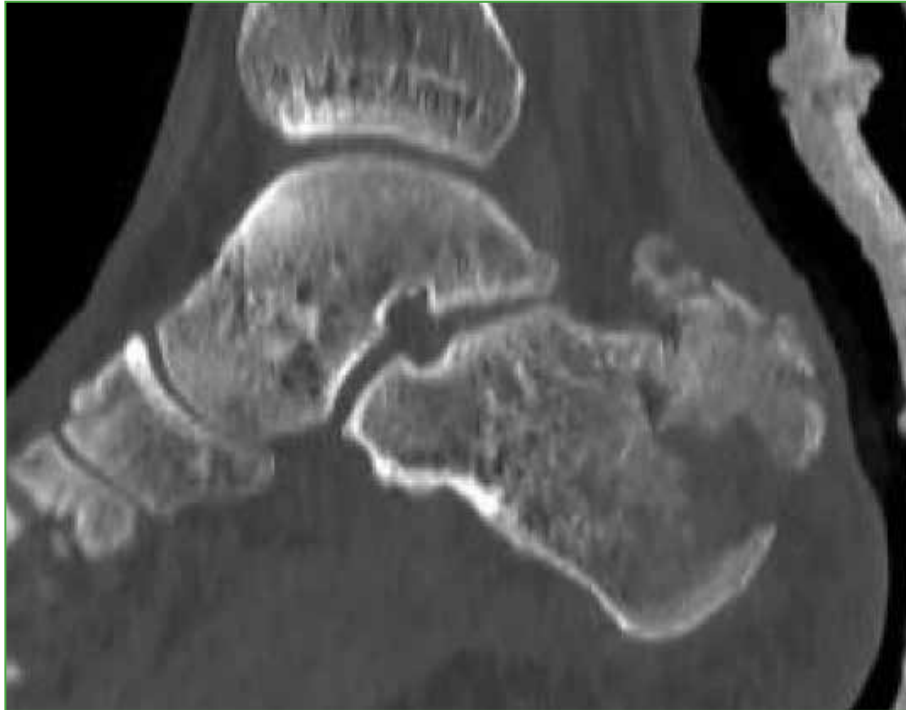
CT scan of the right foot in which a fracture of the posteriorsuperior tuberosity of the calcaneus with a displacement of 1.2 centimeters is observed.
